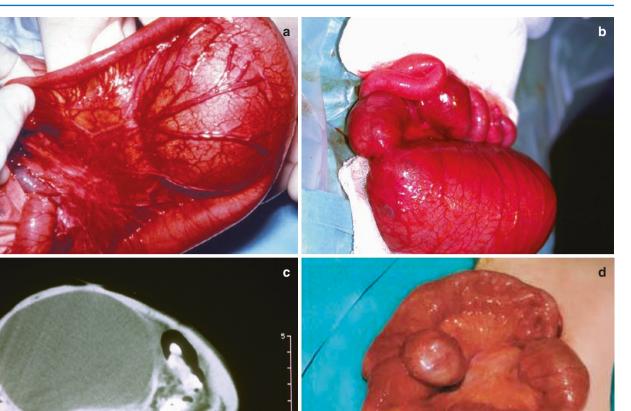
(a) Intraoperative appearance of a small bowel duplication. (b) Duplication cyst small intestine. (c) Omental cyst on CT scan. (d) Meckel's diverticulum
